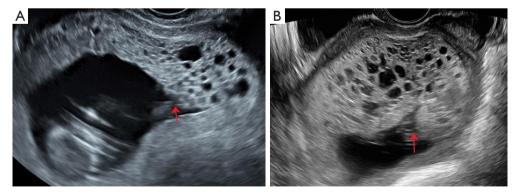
Case 2. (A) Ultrasound image at 15 weeks of pregnancy with PMD. Multiple cystic, anechoic structures are observed within the placental substance. The red arrow indicates the entrance of the umbilical cord into the placenta, and the affected area is situated on the right side of the placental wall, in close proximity to the entrance of the umbilical cord. (B) Ultrasound image at 18 weeks of pregnancy with PMD. The number of cystic, echo-free structures within the placental substance gradually increases. The red arrow points to the entrance of the umbilical cord into the placenta, and the affected area is located above the entrance of the umbilical cord into the placenta. PMD, placental mesenchymal dysplasia.
